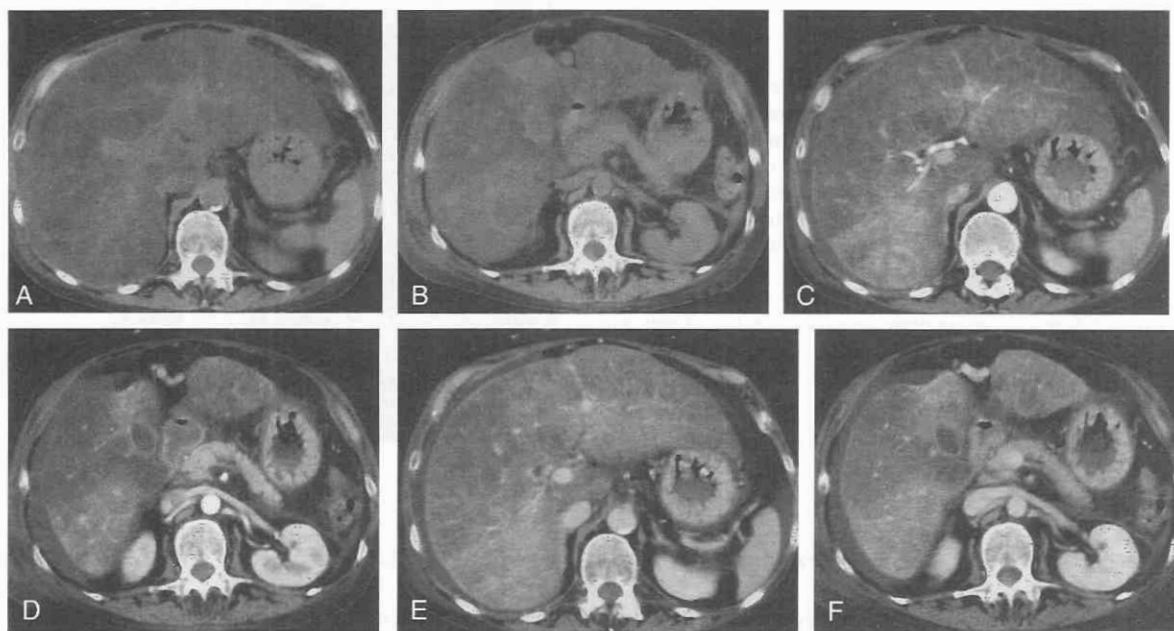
Alcohol-toxic liver cirrhosis in a 56-year-old woman. Unenhanced CT scans (A and B) show reduced attenuation of the hepatic parenchyma, suggestive of steatosis. The parenchyma, particularly in the more caudal sections, is very inhomogeneous. The early arterial contrast phase (C and D) shows irregular, spotty enhancement, which remains visible into the portal venous phase (E and F). Also of note is the significant ramification of the intrahepatic portal vessels.
